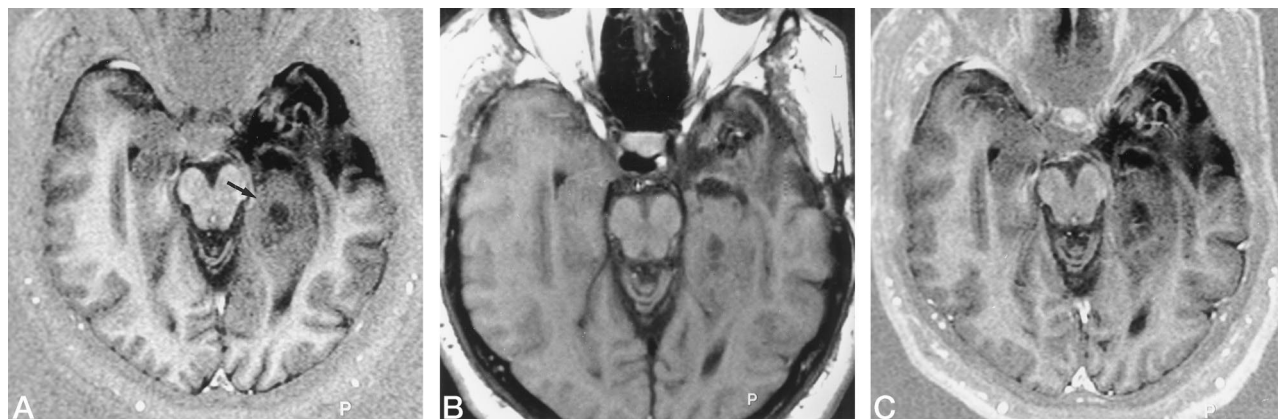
An unenhancing recurrent tumor nodule within the medial left temporal lobe is seen better on noncontrast IR-EPI image (arrow, A) than on noncontrast T1-weighted spin-echo image (B). For comparison, the postcontrast IR-EPI image (C) shows no lesion contrast enhancement. Postoperative encephalomalacia of the anterior left temporal lobe is seen equally well on IR-EPI and T1-weighted spin-echo images.
